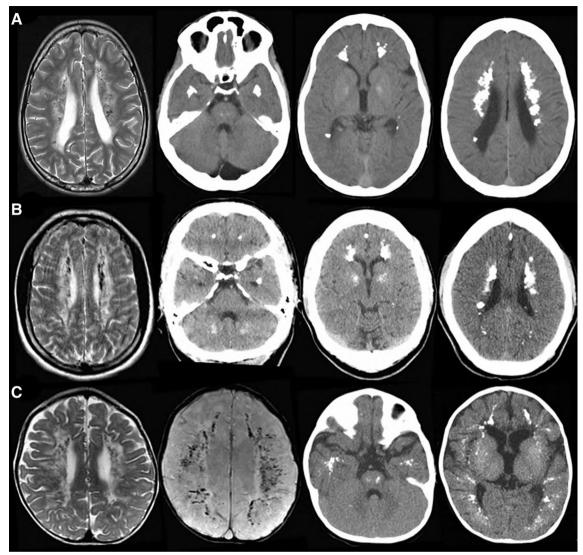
Neuroimaging pattern. (A) Patient 1, T2-weighted magnetic resonance imaging (MRI) (*left*) at 18 years of age shows hyperintensity of the periventricular and deep cerebral white matter, sparing the directly subcortical white matter. Within the abnormal white matter, numerous black dots are present, suggestive of calcium deposits. Computed tomography (CT) at 18 years of age (3 pictures on the *right*) shows numerous small and larger calcifications in the periventricular and deep cerebral white matter, including the temporal lobes. Subtle calcium deposits are present in pons and globus pallidus. The lateral ventricles are slightly dilated. (B) In patient 2, T2-weighted MRI (*left*) and CT (3 pictures on the *right*) at 33 years of age show the same pattern. In this patient, CT also shows calcium deposits in the dentate nucleus, but not in the pons. (C) In patient 5, T2-weighted MRI (*left*) at 20 months of age shows extensive signal abnormalities in the cerebral white matter, containing many black dots, which are suggested to be calcium deposits by susceptibility weighted images (on the *left*, second). The volume of the cerebral white matter volume is reduced with mildly enlarged lateral ventricles and subarachnoid spaces. A CT at 14 months of age confirms numerous small calcifications spread over the cerebral white matter, with also some calcium deposits in the basal nuclei, brain stem, and cerebellum.
